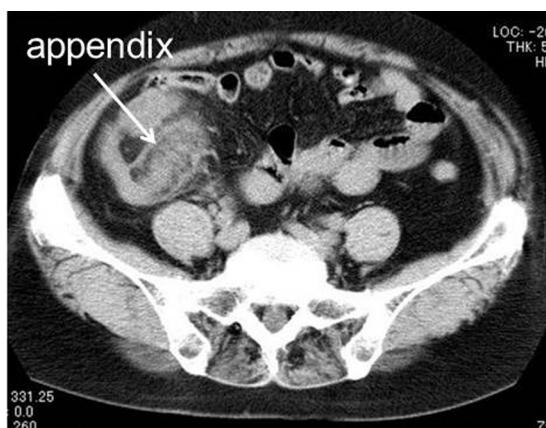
Abdominal computed tomography revealed a swollen appendix, and the surrounding fat tissue showed increased density.
